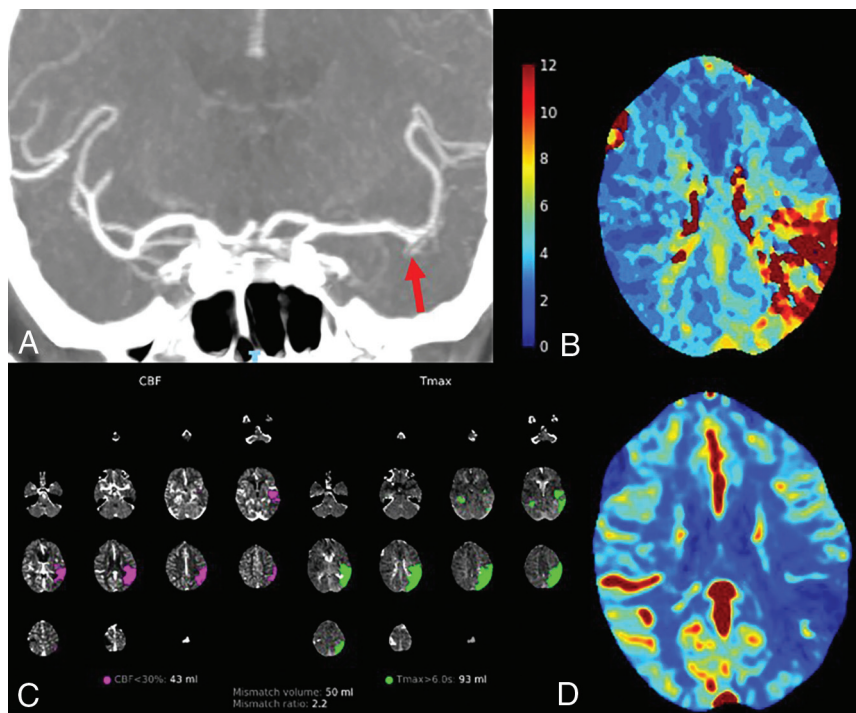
Sample of 40-mL CTP/CTA obtained on a Toshiba 320 scanner. Images from a 79-year-old woman who presented with sudden-onset expressive dysphasia. *A*, MIP CTA images reconstructed from the CTP acquisition at peak arterial opacification demonstrate good opacification of medium and distal intracranial arteries. Proximal occlusion of the left MCA inferior to the M2 division (arrow) is evident. *B* and *D*, Selected slices of Tmax and relative CBF maps show marked territorial Tmax delay and reduced rCBF. The subarachnoid space over the right frontal lobe is focally dilated. *C*, CTP, relative CBF, and Tmax mismatch maps show that there is some salvageable penumbra. Diagnostic-quality CTP was maintained despite contrast dose reduction.
